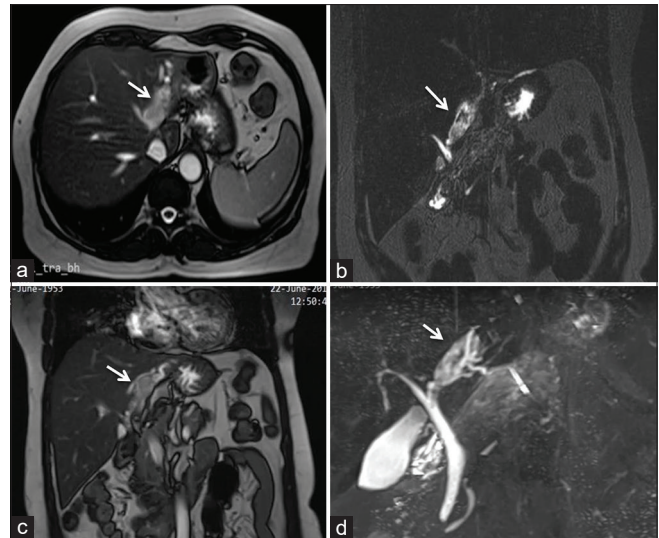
T2-weighted abdominal magnetic resonance images in axial (a) and coronal planes (b and c) show intrahepatic biliary duct ectasia of the left liver lobe accompanied with an area of filling defect within dilated biliary ducts with branching distribution. Magnetic resonance cholangiopancreatography image (d) also shows similar findings
